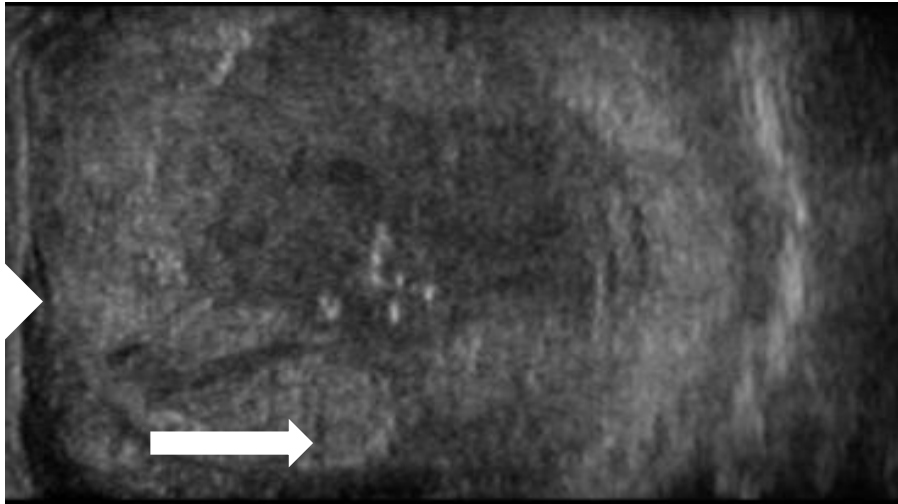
3. On ultrasound, a well-defined solid echogenic lesion in posterior aspect of tongue (broad arrow), with central areas of hypoechogenicity, with few small specs of echogenic calcification (thin arrow) within the lesion.
